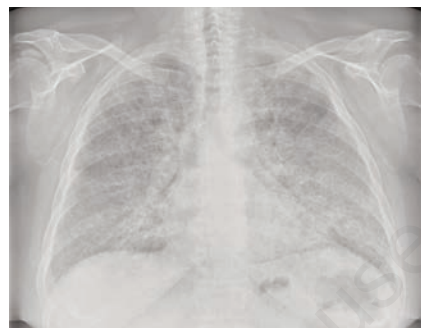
Chest X-ray of March 2017 with evidence of bilateral opacities to the middle and lower lung fields with butterfly pattern and normal lung hilum.
